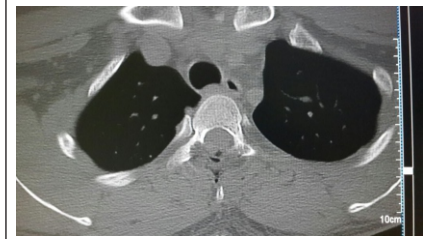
post op CT confirms adequate laminectomy with excision of lesion
